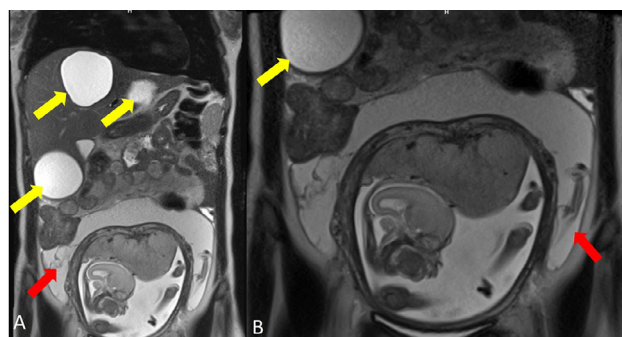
In the unenhanced coronal T2-weighted images, 1 hyperintense type-2 hydatid cyst with hypointense thin-walled membrane surrounding the pregnant uterus at the pelvic region.
